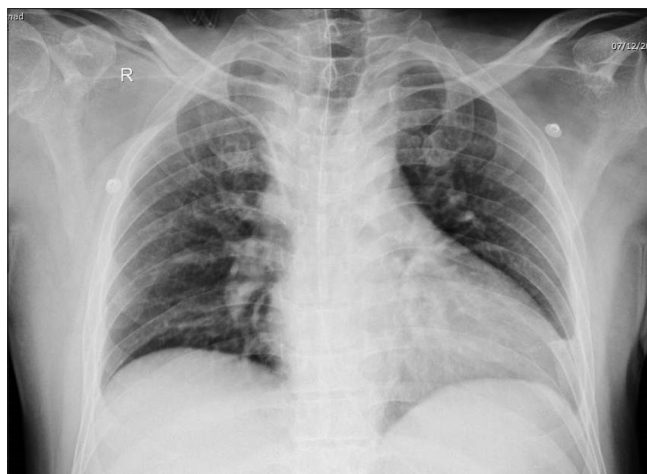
Chest X-ray posteroanterior view showing obscured left costophrenic angle with minimal pleural effusion
